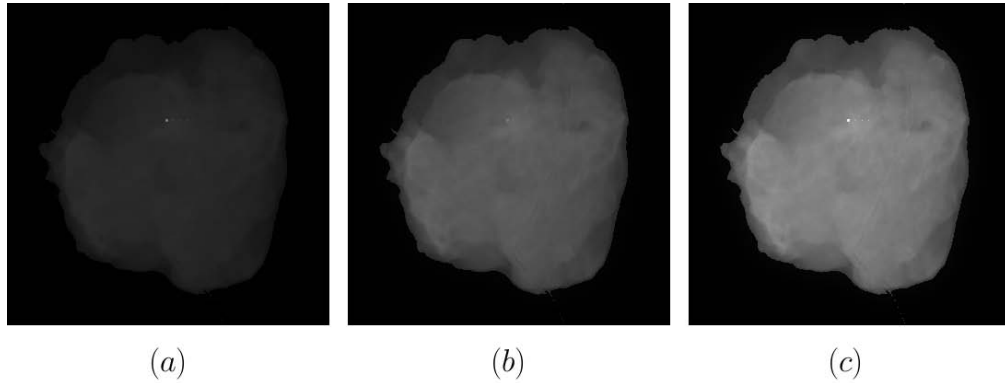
Image manifest of (a)  $A_{pe,coh}^2$ , (b)  $A_{KN}^2$  and (c)  $A_0^2$  when x-ray energy equals 35.5 keV.
